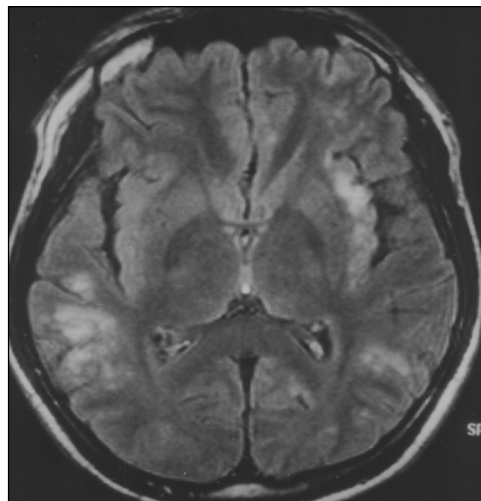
28-year-old man with relapsed Nipah encephalitis. A and B, Fluid attenuated inversion recovery MR images through parietal lobes (A) and temporal lobes (B) show confluent cortical involvement.
